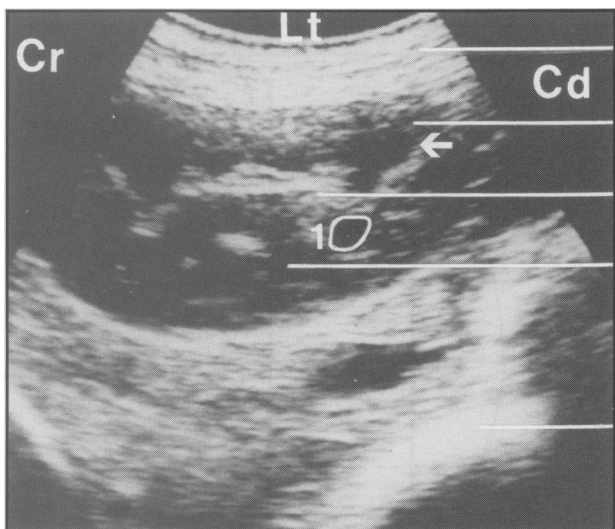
Ultrasonogram of a lateral longitudinal section through the left kidney. Top line = abdominal wall; second line = renal cortex; third line = renal sinus; fourth line = medullary pyramid; bottom line = ruminal wall; arrow = renal medulla; Cd = caudal; Cr = Cranial; Lt = lateral; 1 = circumference of a medullary pyramid.
